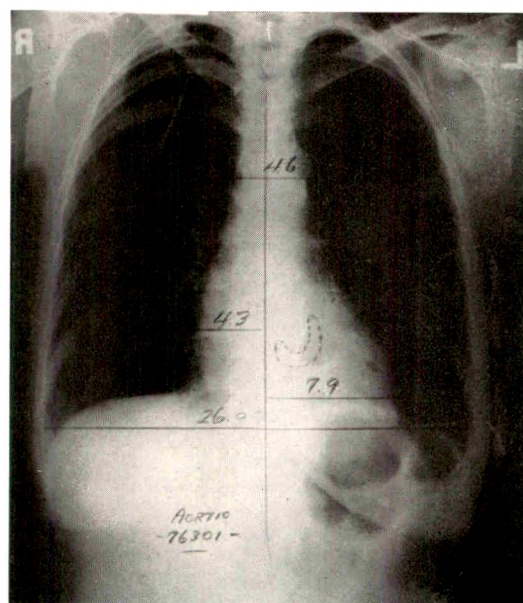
Aortic stenosis with calcification. Seven-foot film, valve outlined from roentgenoscopic tracings (Case VII).
